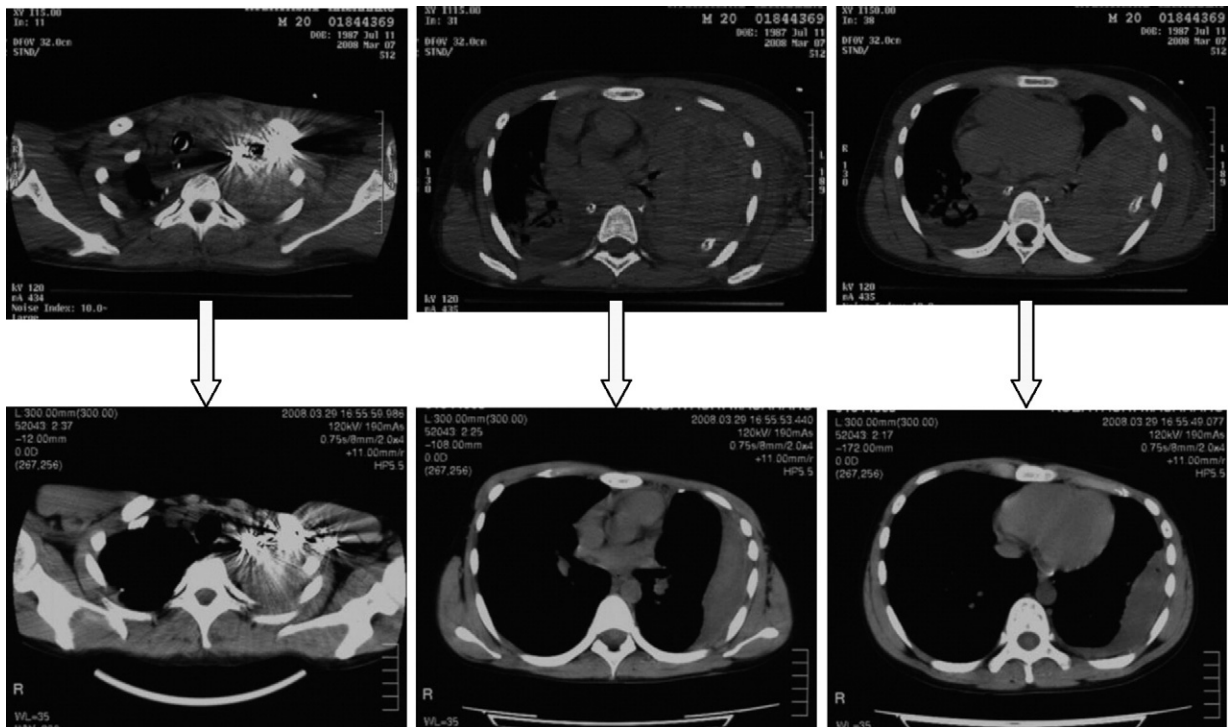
A comparison of (Top row) preoperative computed tomography images with (Bottom row) follow-up images shows improvement of the hematoma in the left hemithorax.
